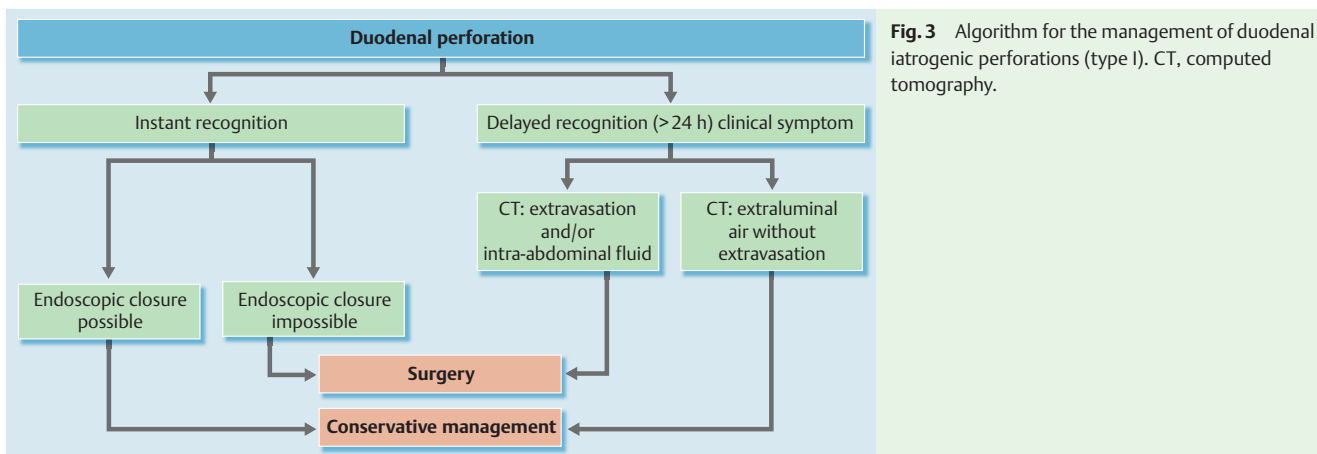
Algorithm for the management of duodenal iatrogenic perforations (type I). CT, computed tomography.
